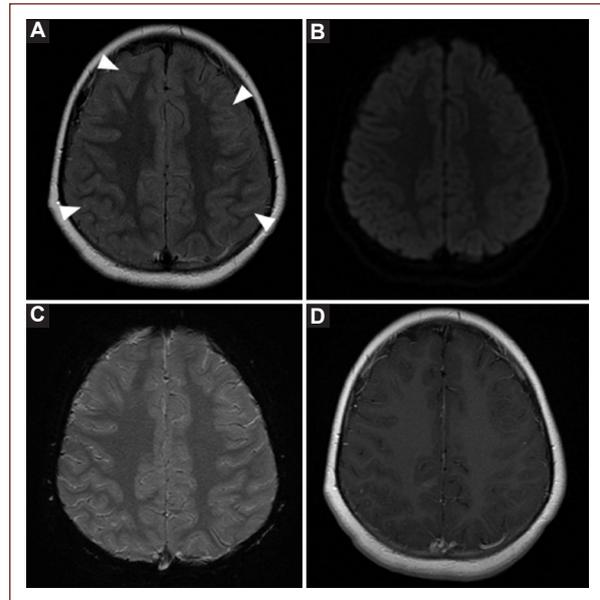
Brain magnetic resonance imaging. A: axial T2 fluid-attenuated inversion recovery shows subtle diffuse sulcal hyperintensity (white arrowheads), without parenchymal lesions. No abnormalities in B: diffusion-weighted image; C: GRE T2-weighted image, and D: gadolinium-enhanced T1-weighted image.
